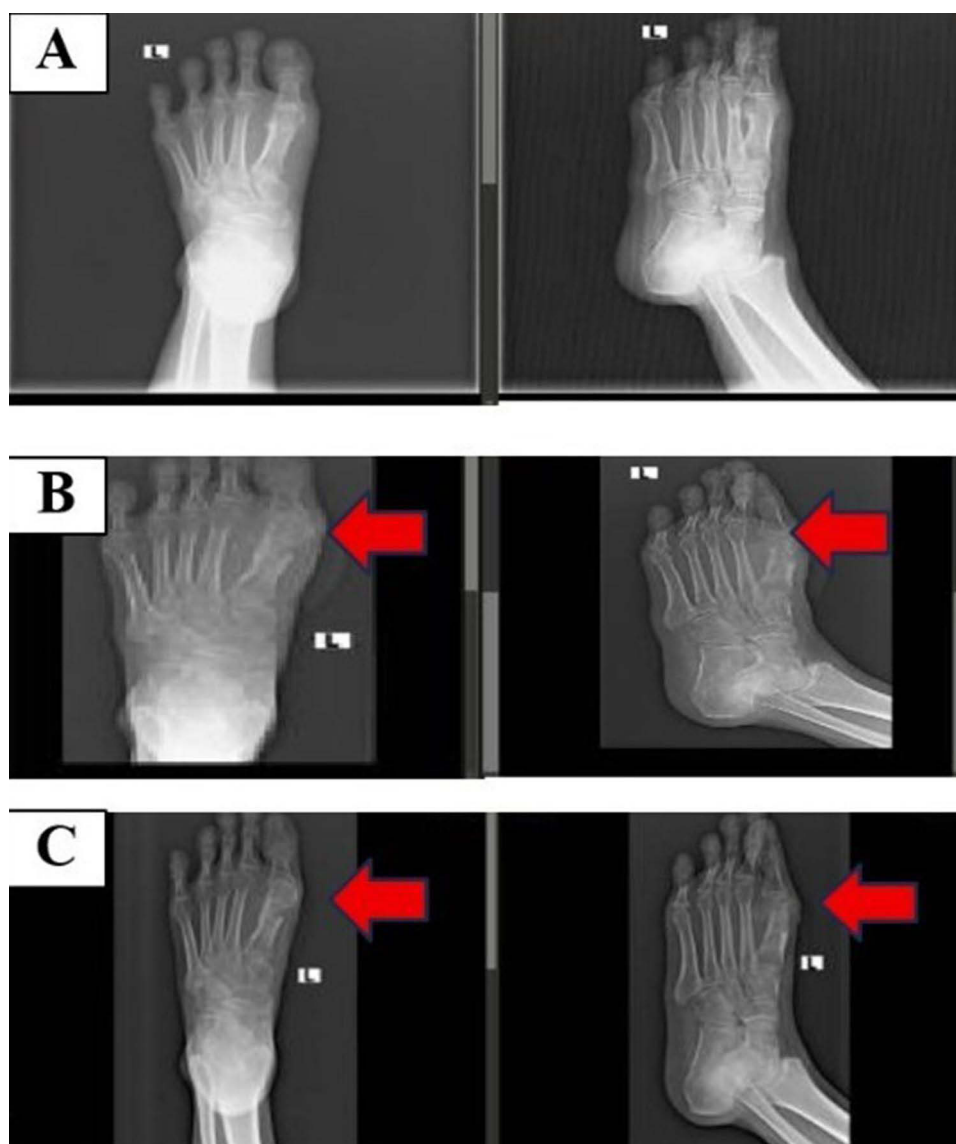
Left foot X-ray (anteroposterior and oblique views). (A) Radiograph of the left foot dated 16 August 2024 shows normal findings with no evidence of bony involvement. (B) Radiograph dated 30 July 2025 demonstrated soft tissue swelling accompanied by a destructive osteolytic lesion at the distal part of the first metatarsal bone of the left foot, indicating osteomyelitis (red arrow). (C) Radiograph dated 9 October 2025 reveals persistent soft tissue swelling and an osteolytic lesion at the distal first metatarsal of the left foot (red arrow), with interval improvement in the degree of swelling compared to image B.
